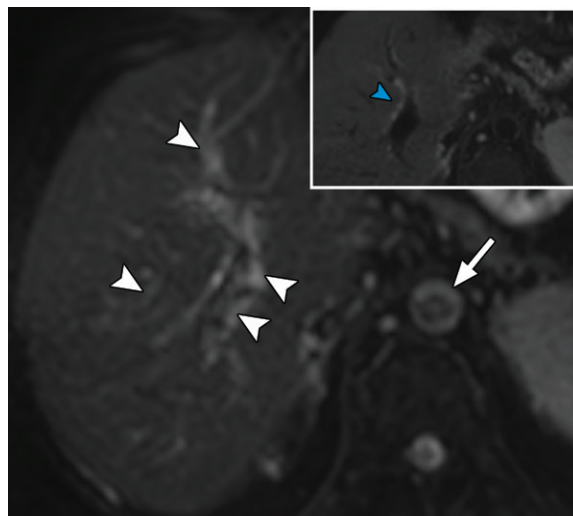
Effects of different low b values at DWI of the liver in a 58-year-old man who underwent liver MRI. Axial diffusion-weighted image with a b value of $0 \text{ sec}/\text{mm}^2$ shows heterogeneous signal intensity in the various blood vessels of the liver (white arrowheads) and the periphery of the aorta (arrow) owing to slow flow. Applying a b value of $50 \text{ sec}/\text{mm}^2$ (inset) removes vascular signal intensity, resulting in a cleaner image where the bile duct adjacent to the portal vein (blue arrowhead) is visible and background liver signal intensity is homogeneous, allowing better detection of subtle abnormalities.
